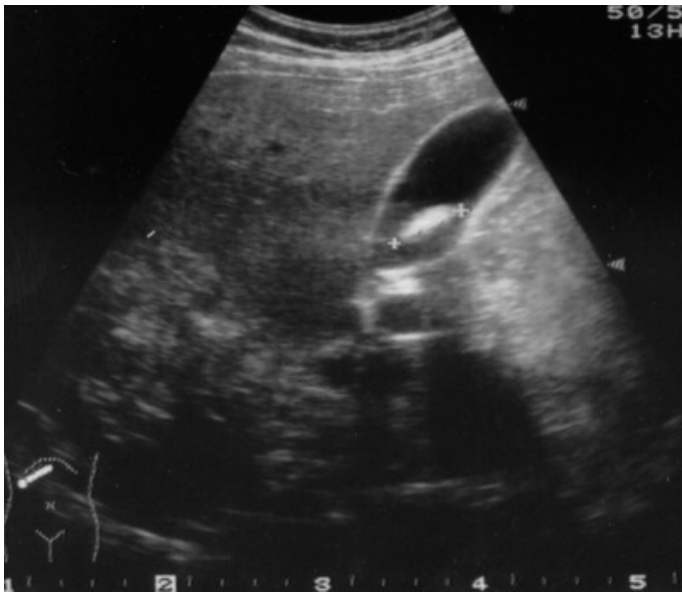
Gallstones on ultrasound
